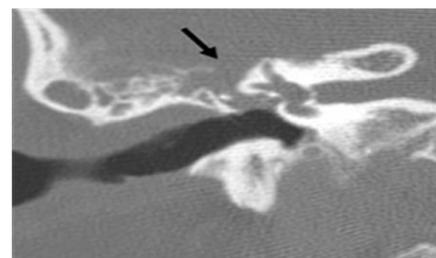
Giant cell tumor coronal cut right temporal CT scan. Soft tissue lesions appear in the attic and tegmental air cells with the distribution of damage to tympani tegmen (arrow)
